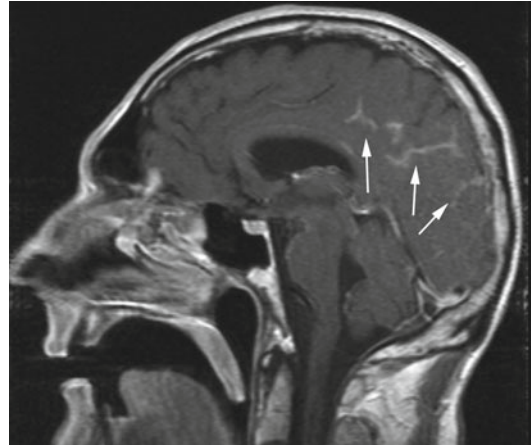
Leptomeningeal carcinomatosis. Sagittal gadolinium-enhanced T1-weighted image reveals meningeal enhancement along the sulci of the posterior cerebral cortex (*arrows*)
